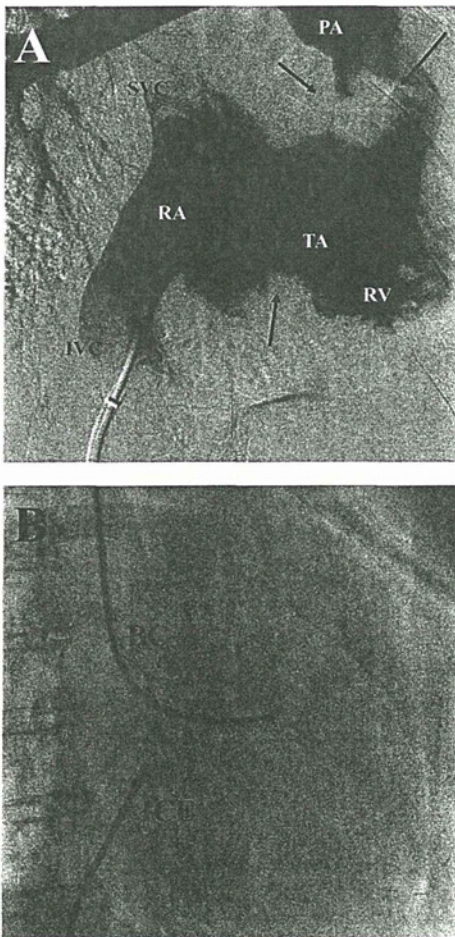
Right anterior oblique (RAO) view of a right atrium (A) showing the cardiac tumor (black arrows) protruding into the right atrium (RA) and right ventricle (RV), and causing an RV outflow tract obstruction. RAO view of a fluoroscopic image (B) shows the location of the biopsy catheter (BC) next to the cardiac tumor and the intracardiac echocardiography (ICE) catheter in the RA. PA, pulmonary artery; TA, tricuspid valve annulus; SVC, superior vena cava; IVC, inferior vena cava.
